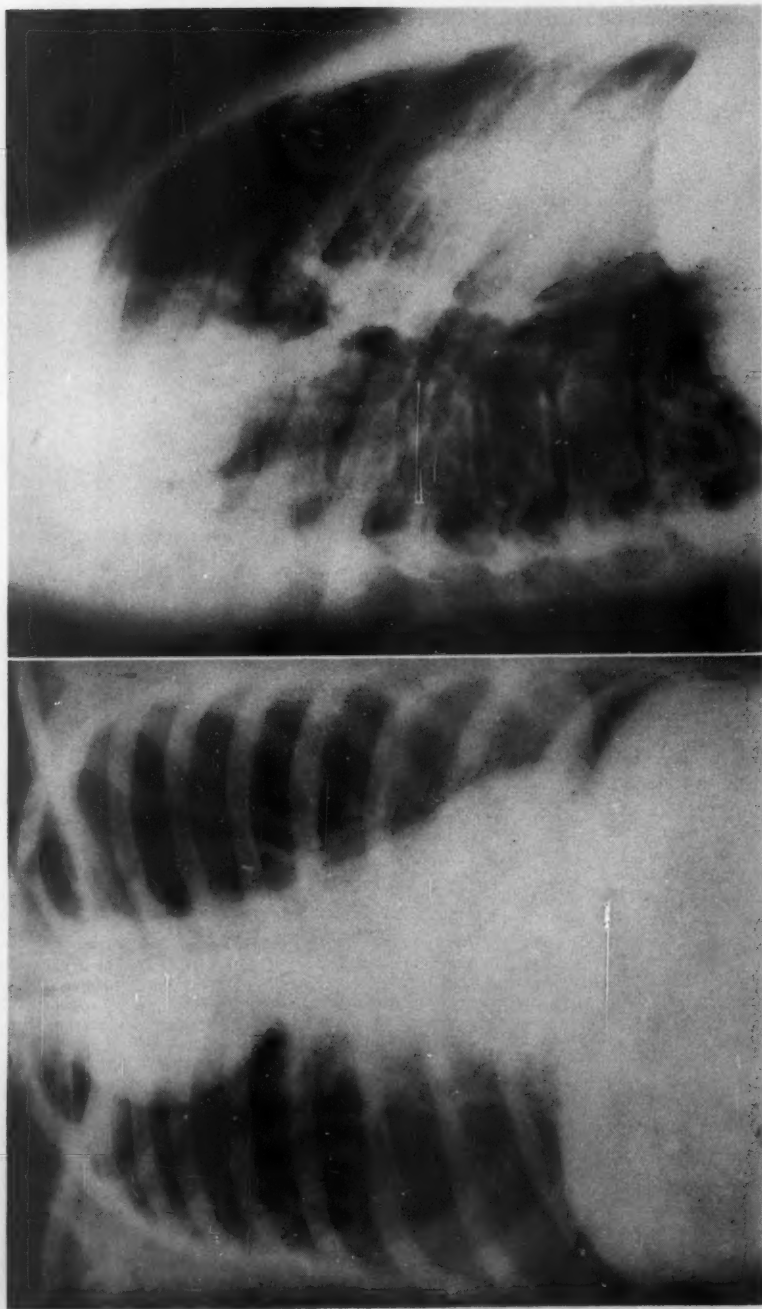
(left) The posterior-anterior chest roentgenogram of a 32 year old male who complained of frequent colds, with one episode of hemoptysis. A large density with a smooth border extension from the right superior mediastinum. On fluoroscopy the density was noted to change size on respiration, becoming larger on inspiration.
